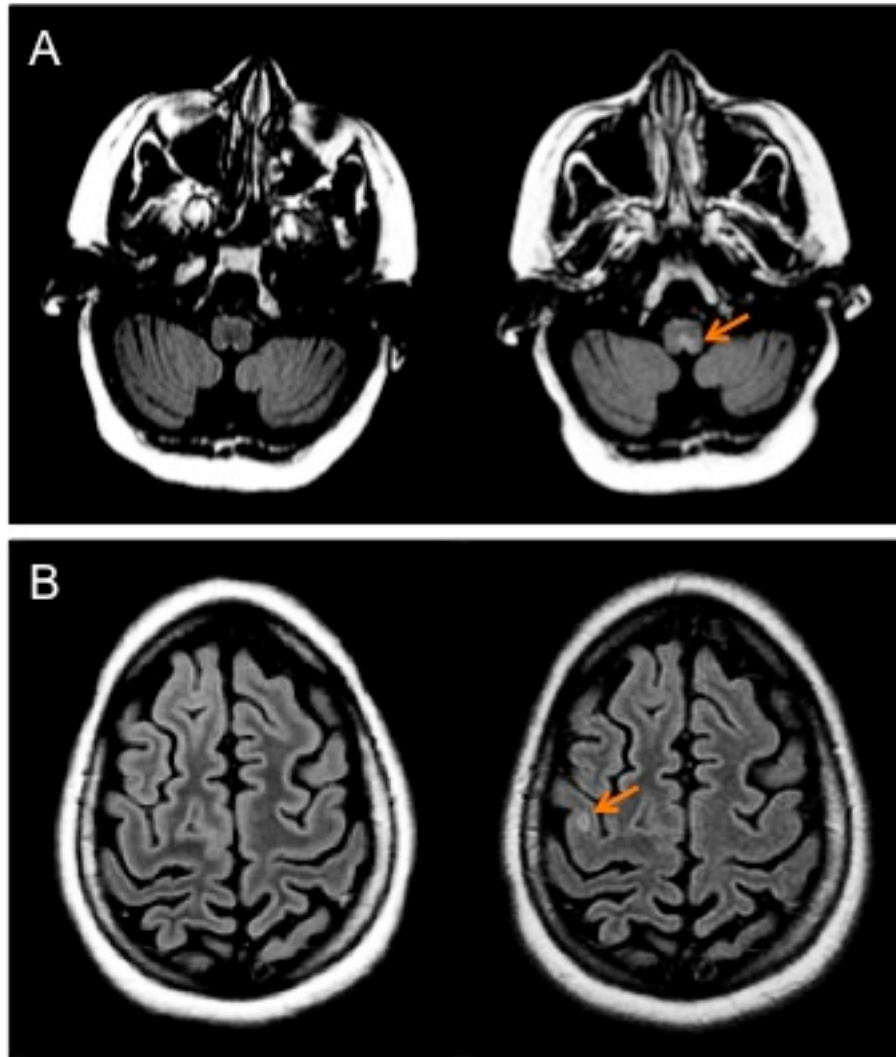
Detection of new lesions in portions of the brain often not imaged in clinical MRI protocols. Axial FLAIR images of a girl with MS who presented with a first attack at age 11 years. (A) A new T2 lesion is visible in the medulla when compared to the previous scan acquired 6 months earlier. (B) In the same patient, a new juxtacortical lesion is visible when compared to the previous scan 2 years prior.
